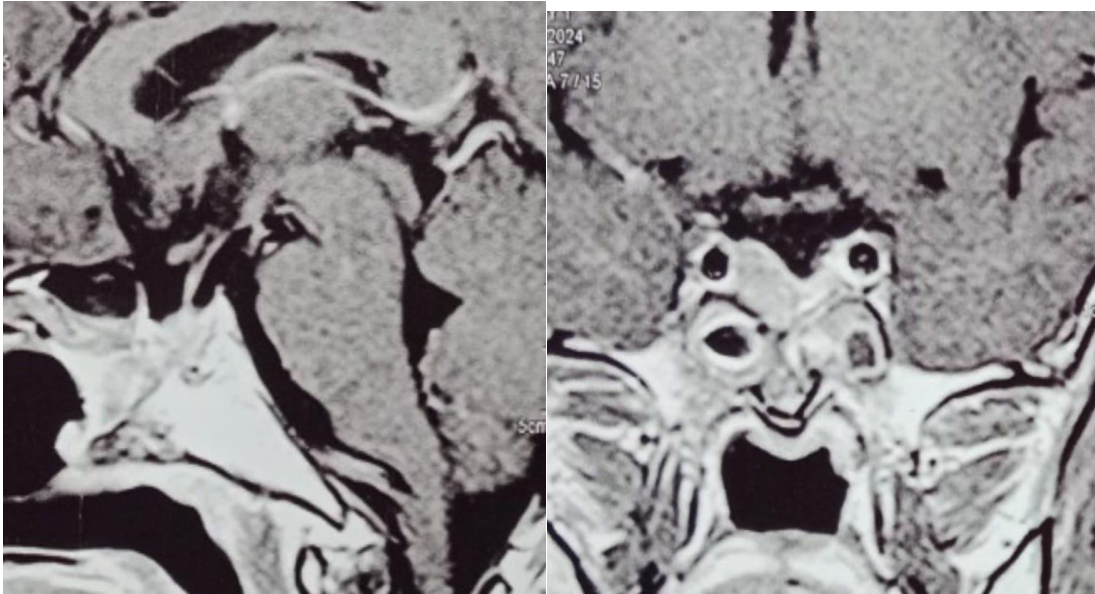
MRI T1 sagittal and coronal views postoperative demonstrates subtotal excision of recurrent macroadenoma.
